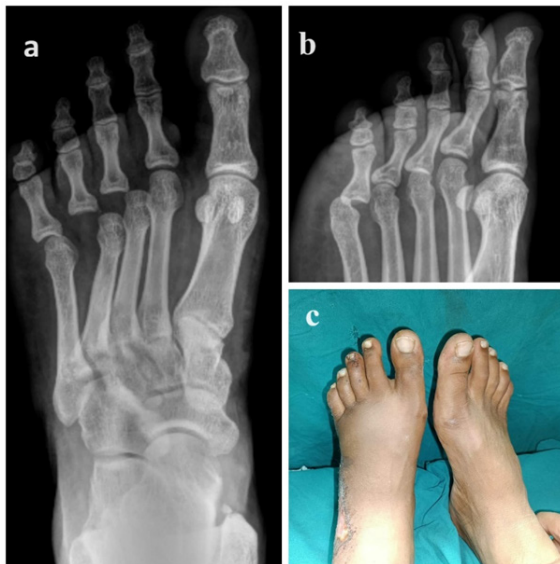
Radiographs of foot. (a) Anterior-posterior view, (b) Oblique view, (c) Clinical picture of patient.
